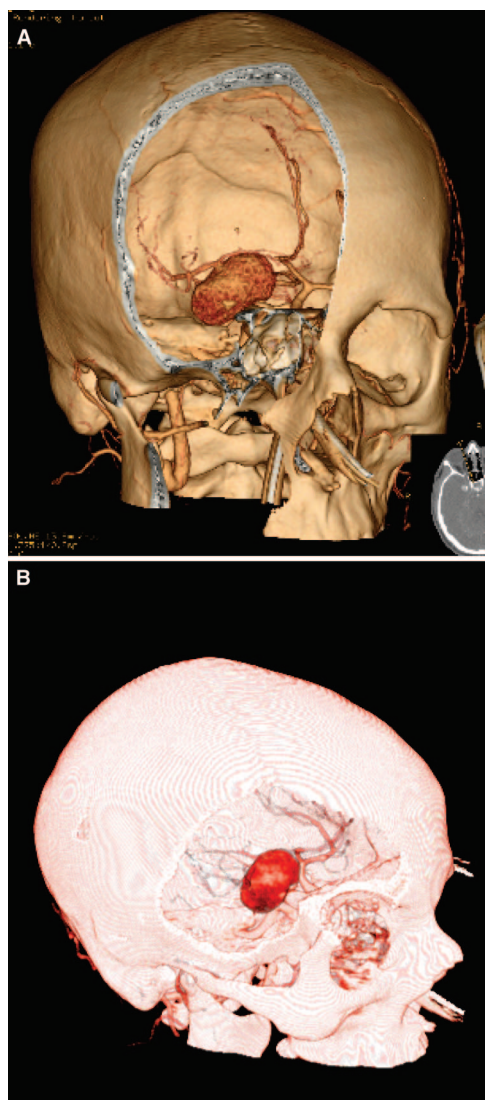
Advances in imaging. A, computed tomographic angiogram of a giant right ICA aneurysm in this young patient with subarachnoid hemorrhage. B, dextroscope imaging of this same patient can be used to determine the surgical accessibility of the proximal and distal carotid artery for a trapping or bypass procedure.
